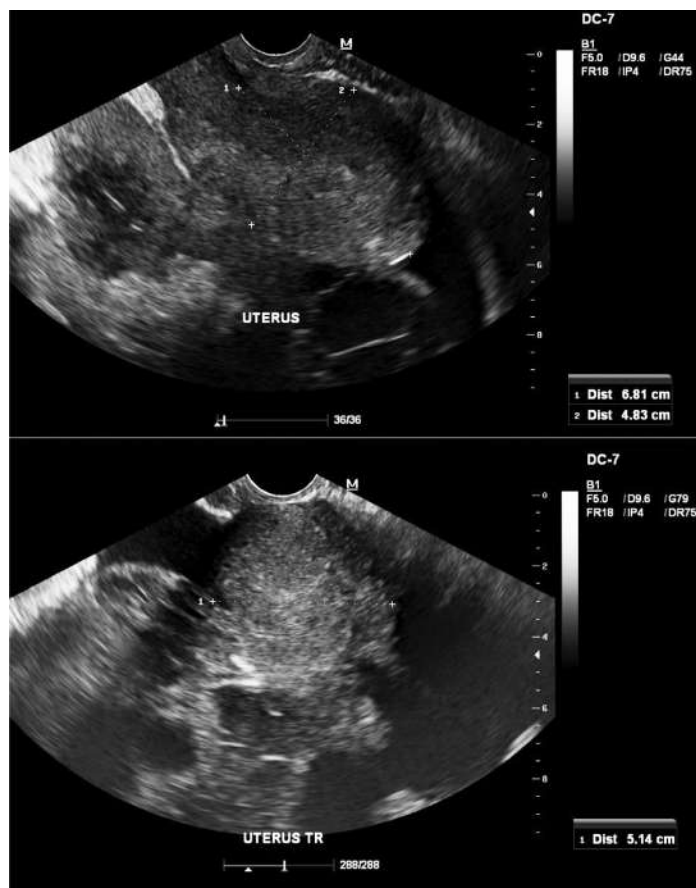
Transvaginal Ultrasound showing endometrial cancer with ovarian involvement
